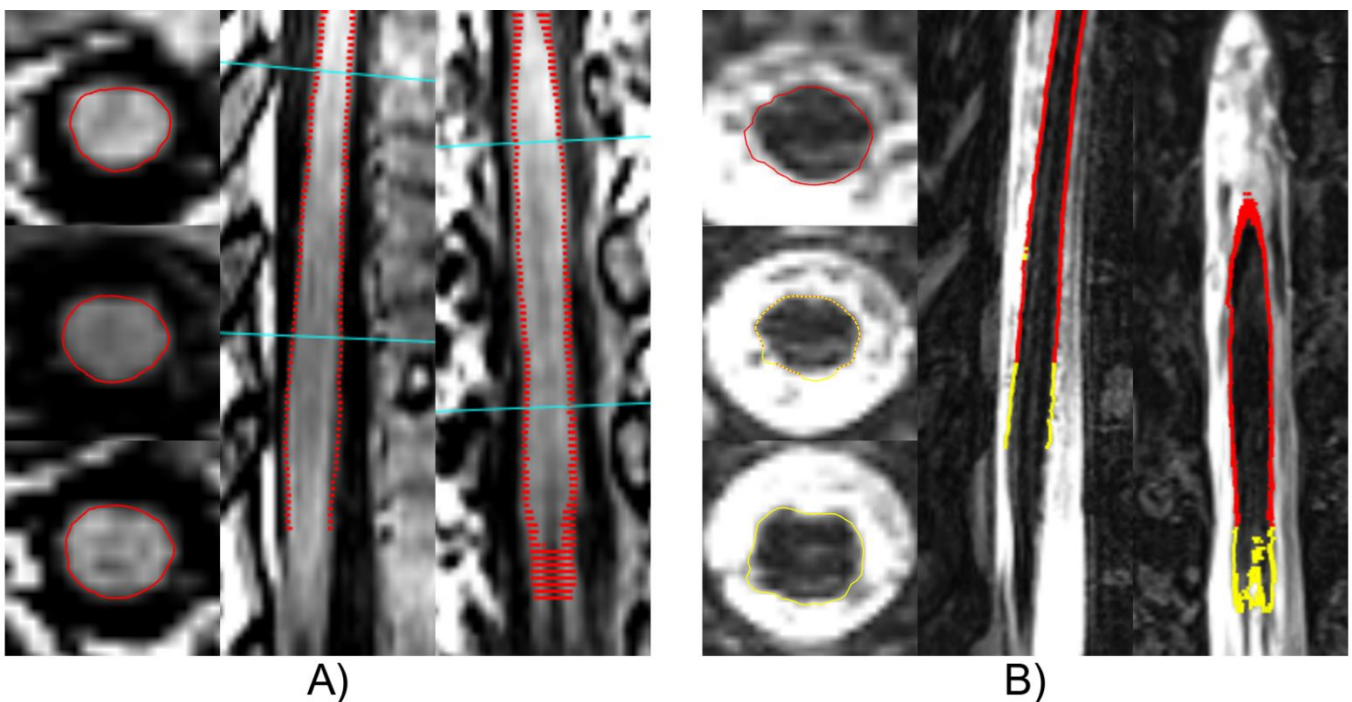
Lumbar spinal cord (SC) segmentation (red lines) using *Cordial* in a representative subject. A) Successful segmentation on 3D T1-weighted fat-suppressed VIBE images. As demonstrated in the sagittal image, *Cordial* aborts the segmentation in the region of the conus medullaris. Of note, *Cordial* shows a rather conservative segmentation with its outer boundary slightly within the cord's surface. B) *Cordial* failed to deliver high quality segmentations of the whole lumbar SC in 3D T2-weighted SPACE images of the same subject due to artifacts based on the spinal nerve roots exits and nerve roots adjacent to the spinal cord within this region.
